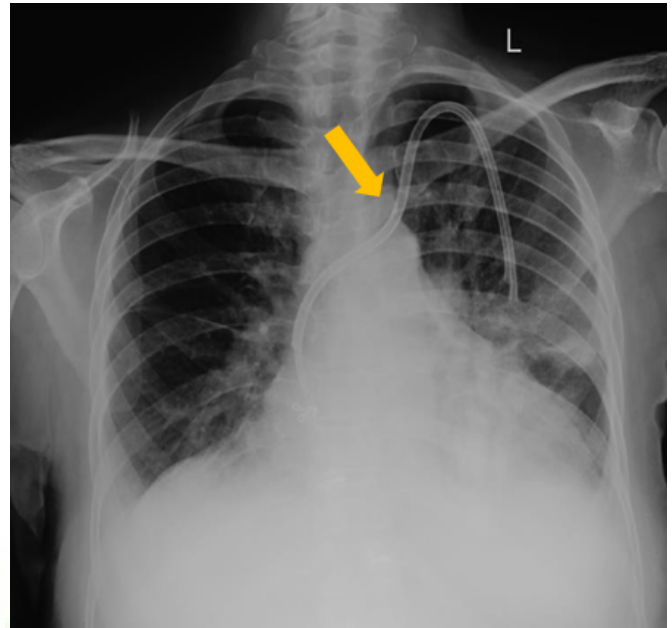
Left IJVpermcatheter. In this case, the both IJVs were thrombosed and USG guided puncture was done at the IJV-SCV junction, after confirming patency on Doppler.
